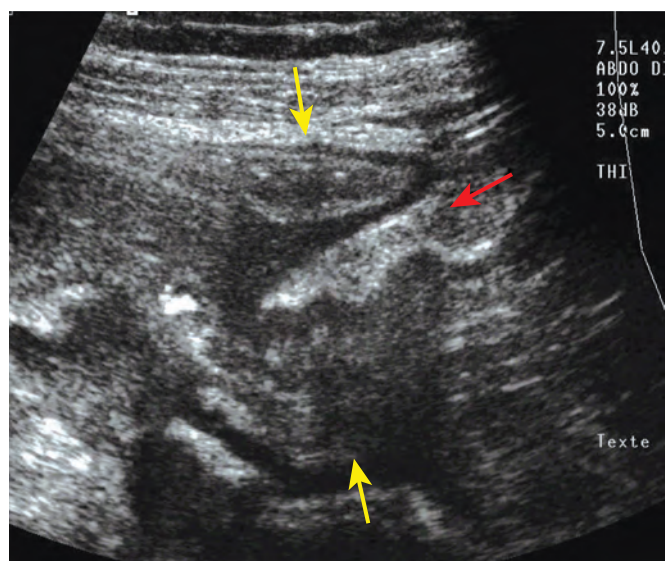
Fibrostenosing Crohn's disease: Sonographic features. Marked thickening of a segment of ileum (yellow arrows) is identified, causing dilation of the proximal small bowel (red arrow). (Courtesy of Dr. Pierre-Jean Valette, Lyons, France.)
